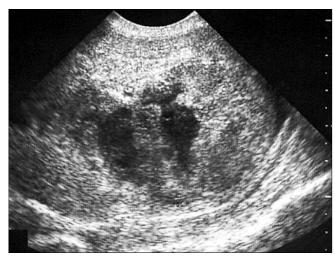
Abdominal ultrasound shows left liver lobe tumour, 5 cm in diameter.
